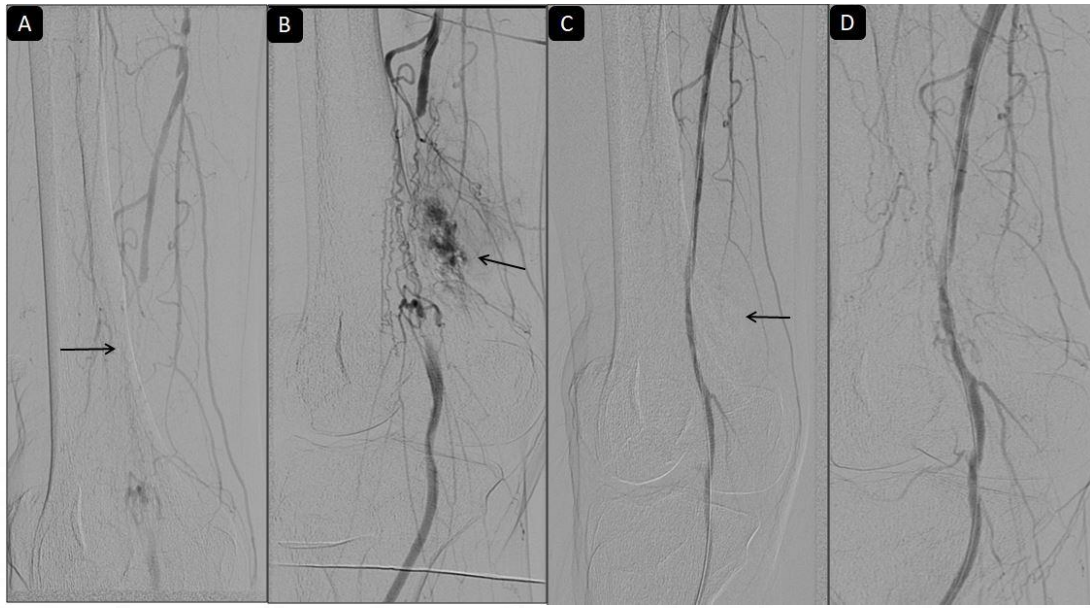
A)CTA showing flush occlusion of right SFA with a very small proximal stump(arrow). B and C)Angiogram from left CFA retrograde approach revealed calcified flush occlusion of right SFA(arrow in B), with reformation in adductor SFA(arrow in C). After failed attempt in crossing the lesion from retrograde approach, right PTA was cannulated and planned to proceed with SAFARI technique(D). E and F) The terumo wire from PTA approach was captured and snared(arrow in F) into the cross over sheath from left CFA and a through and through access was achieved. G) Followed by SUPERA stent deployment covering the reentry site with good flow across the stent
